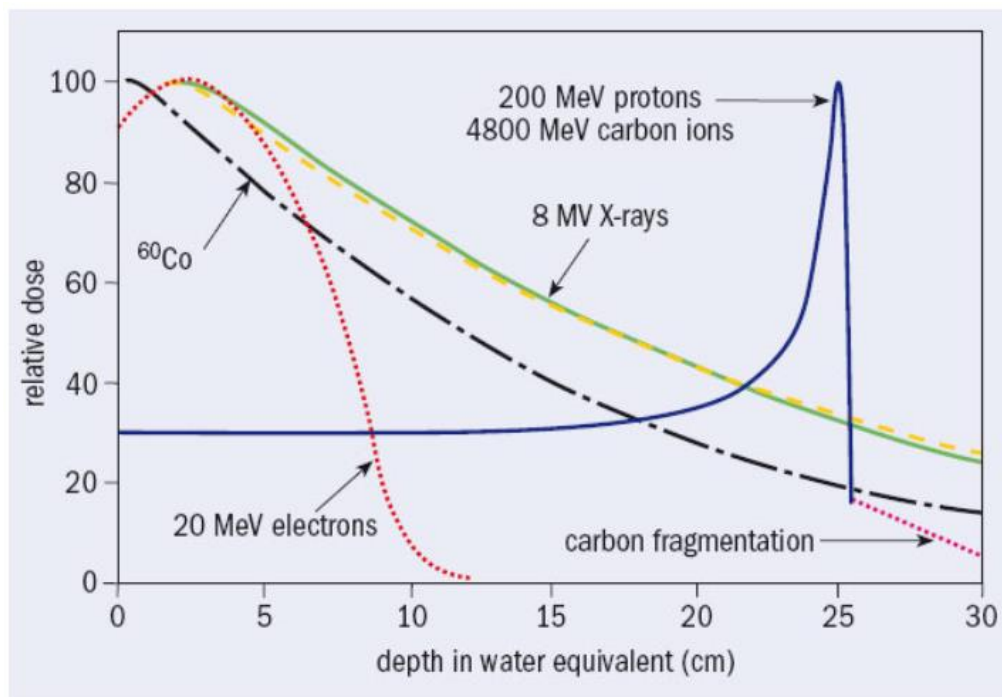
Depth dependence of the deposited dose for different radiations. Because of the Bragg peak it is said that the dose distribution is 'inverted' with respect to the almost exponential, and much less favourable, behaviour produced by X-rays. Source: Amaldi & Kraft, 2005.
